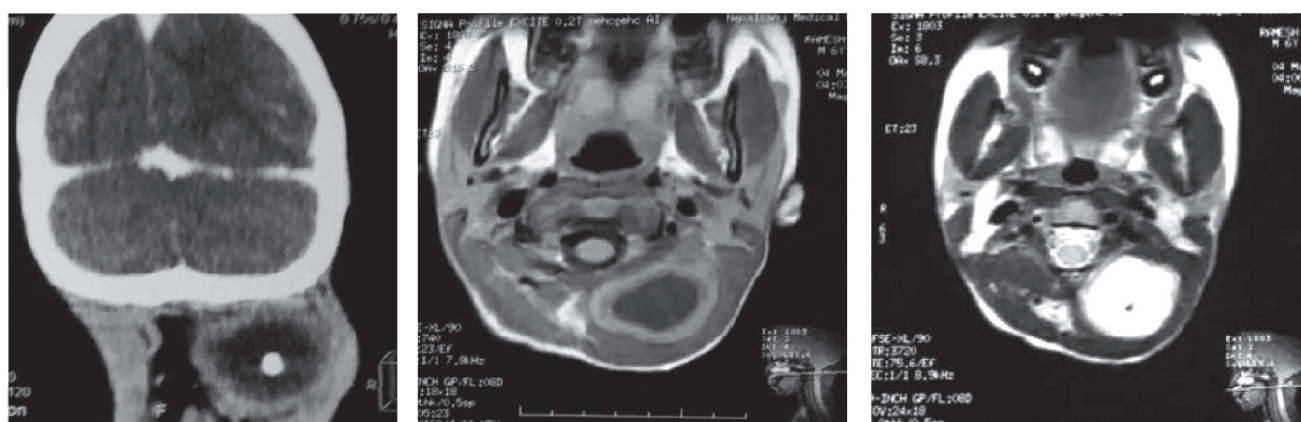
CT scan (A) showed hypodense, non-enhancing lesion with calcification in left posterior cervical region abutting posterior arch of C1. MRI revealed hypointense lesion on T1- (B) and hyperintense on T2-weighted (C) images.
